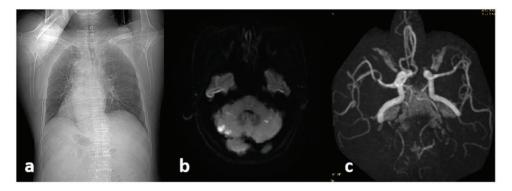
Imaging examinations of the male patient reported in this case. a: Chest and abdominal X-ray examination confirmed dextrocardia. b: Diffusion-weighted imaging of brain magnetic resonance indicates acute infarction of bilateral cerebellar hemispheres. c: Brain magnetic resonance angiography showed bilateral vertebral artery and basilar artery occlusion.
